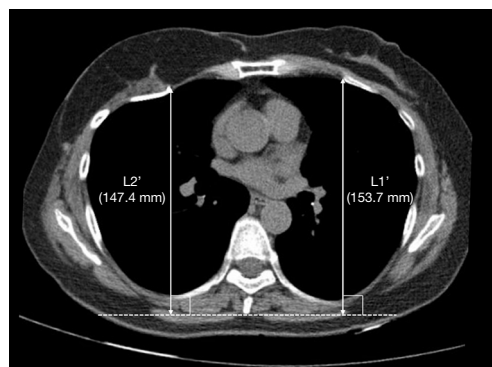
Postoperative CT image. CT scan at the 12-month follow-up showed reconstructed right breast with autologous tissue and recoiling of right chest wall (right side, 147.4 mm; left side, 153.7 mm). Estimated recoiled length was approximately 17.2 mm. Estimated recoiled length = $L2' - L2 \times (L1'/L1) = 147.4 - 127.2 \times (153.7/150.2) = 17.2$ mm. L1': postoperative left chest wall; L2': postoperative right chest wall. CT, computed tomography.
